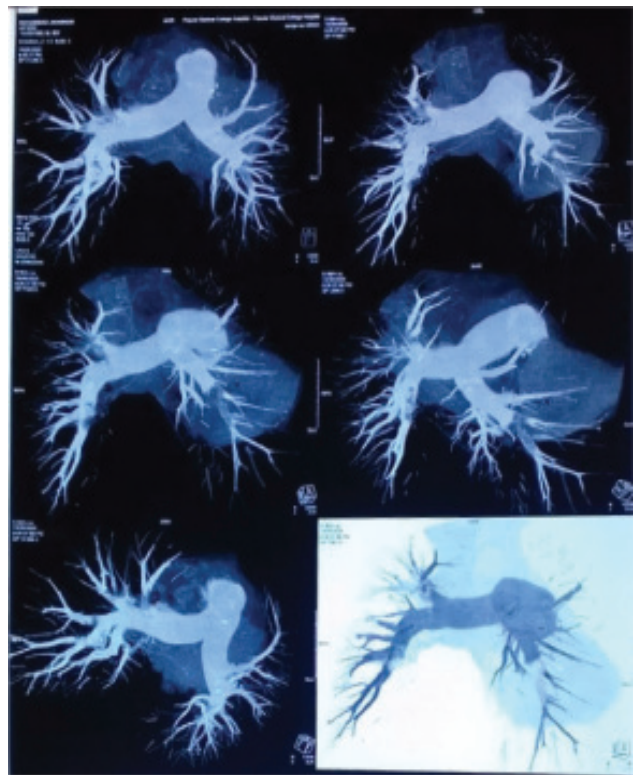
CT pulmonary angiogram showing filling defect in right upper lobar, right lower lobar segmental branches and left lower lobar segmental branches
